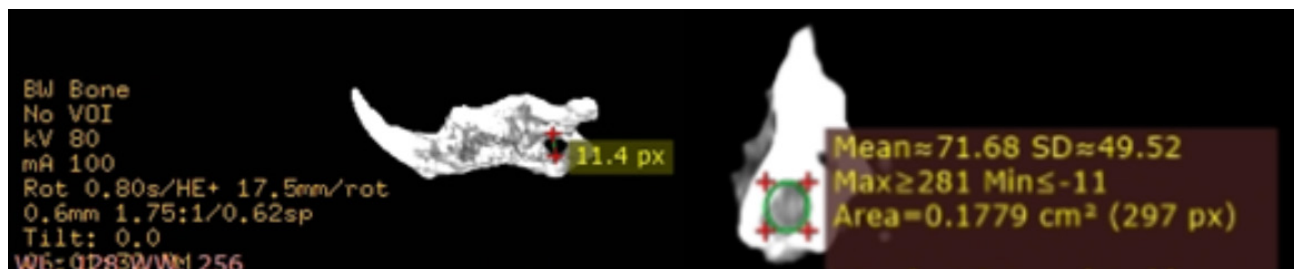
Calculation of HU from PET/CT images: Cross-section view of the mandibular bones.
